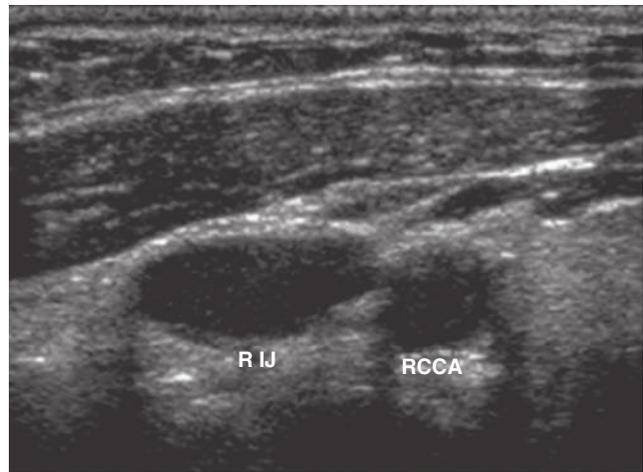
Transverse view of normal anatomy of the right internal jugular (RIJ) vein and right common carotid artery (RCCA). Ultrasound examination helps determine the anatomic relationship, size, and patency of the vessels. Knowledge of these important vessel characteristics helps determine if the anatomy is suitable for central vein catheterization at a low risk. If the vessel anatomy is normal and the operator is experienced, subsequent venous catheterization can be done by the surface landmark technique or under real-time ultrasound guidance. If high-risk characteristics are identified (see Box E2.6), however, real-time ultrasound guidance (or selection of a different access site) would be preferred. (Courtesy Dr. Kurian Puthenpurayil.)
